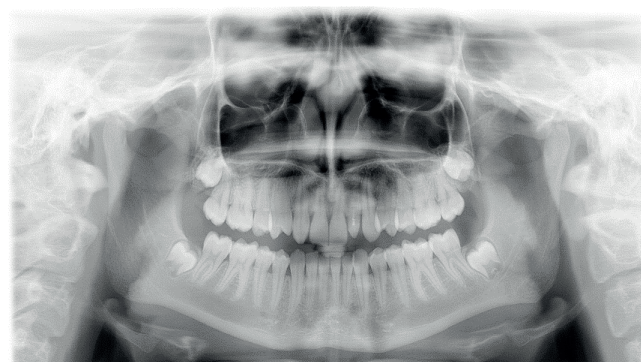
Panoramic radiograph made during the last follow-up visit. The patient is 15 years old
